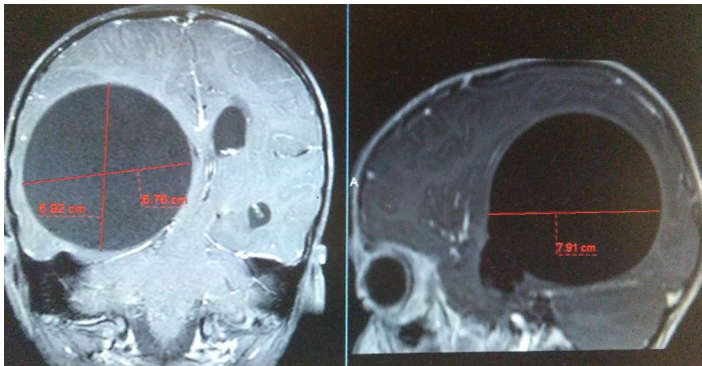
T1- and T2-weighted MR images of cerebral hydatid cyst
